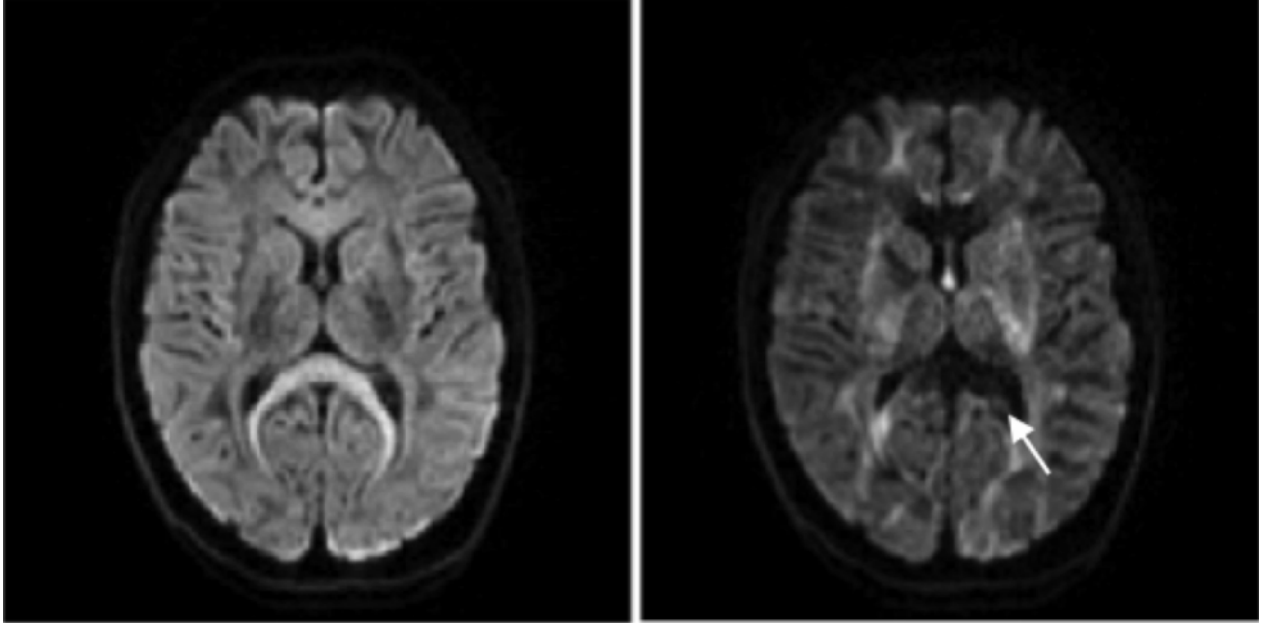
DWI obtained with different gradient directions. Axial DW image obtained using gradient only along the z axis (image left) and only along the x axis (image right). The signal drops when the direction of the water molecules is parallel with the gradient direction (hypointensity in the splenium of corpus callosum, image right). On the other hand the signal increases when the direction of the diffusion of the water molecules is perpendicular to the gradient direction (hyperintensity in the corpus callosum image left). Image reproduced from [ISMRM blog](#).
